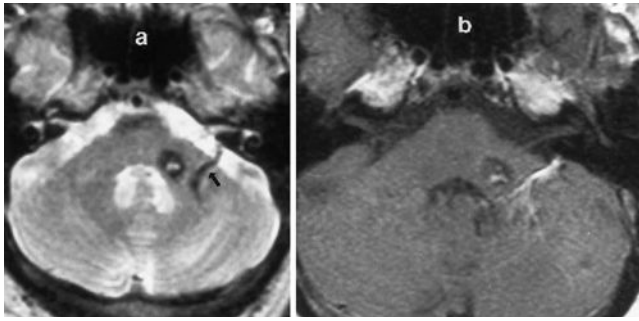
Magnetic resonance images in a 38-year-old man with a cavernous malformation medial to a venous malformation within the left middle cerebellar peduncle. a: Long-TR image showing the mixed-signal cavernous malformation and a flow-void area within the transparenchymal draining vein (*arrow*) of the venous malformation. b: Short-TR image with contrast enhancement showing the radial collection of venous channels within the venous malformation.
